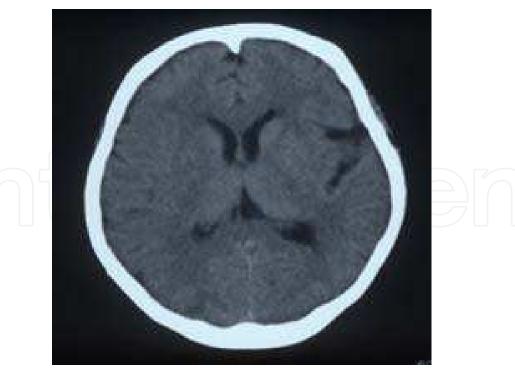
CT scan demonstrating early CT findings of acute ischemic stroke (within 3 hours from onset) - slight changes, right sulci and Sylvian fissure effacement - effacement of R insular islands and structures of basal ganglia
